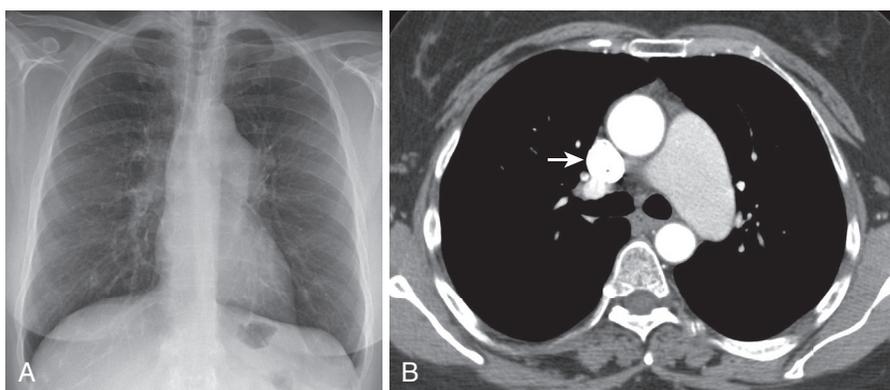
Congenital pulmonic stenosis. A, PA chest radiograph shows poststenotic dilation of the left pulmonary artery. Right pulmonary artery is normal. B, Axial CT image confirms enlargement of left pulmonary artery (arrow).
